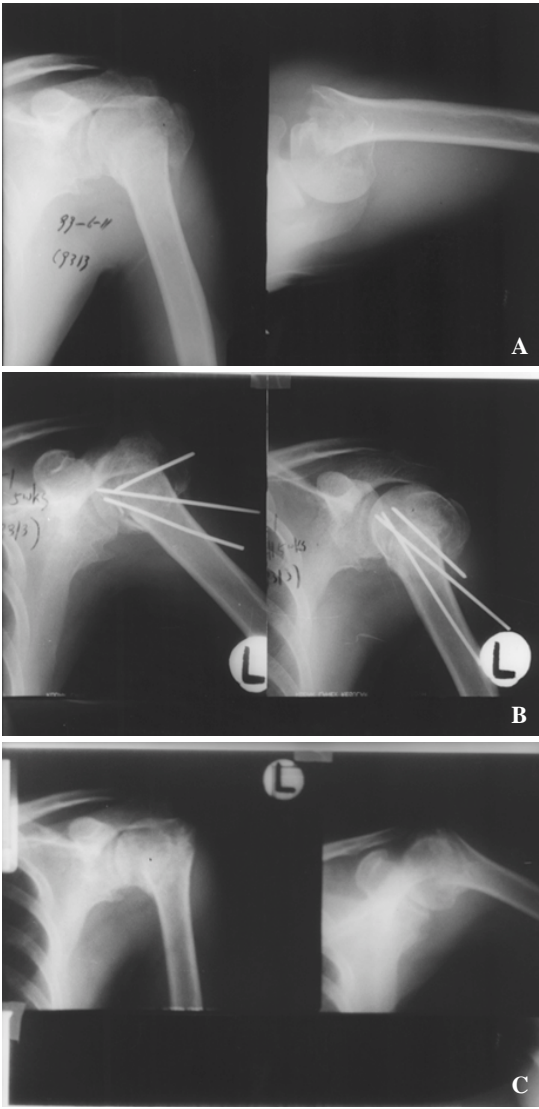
The preoperative radiograph of 58-year-old man shows comminuted proximal humerus fractures.
